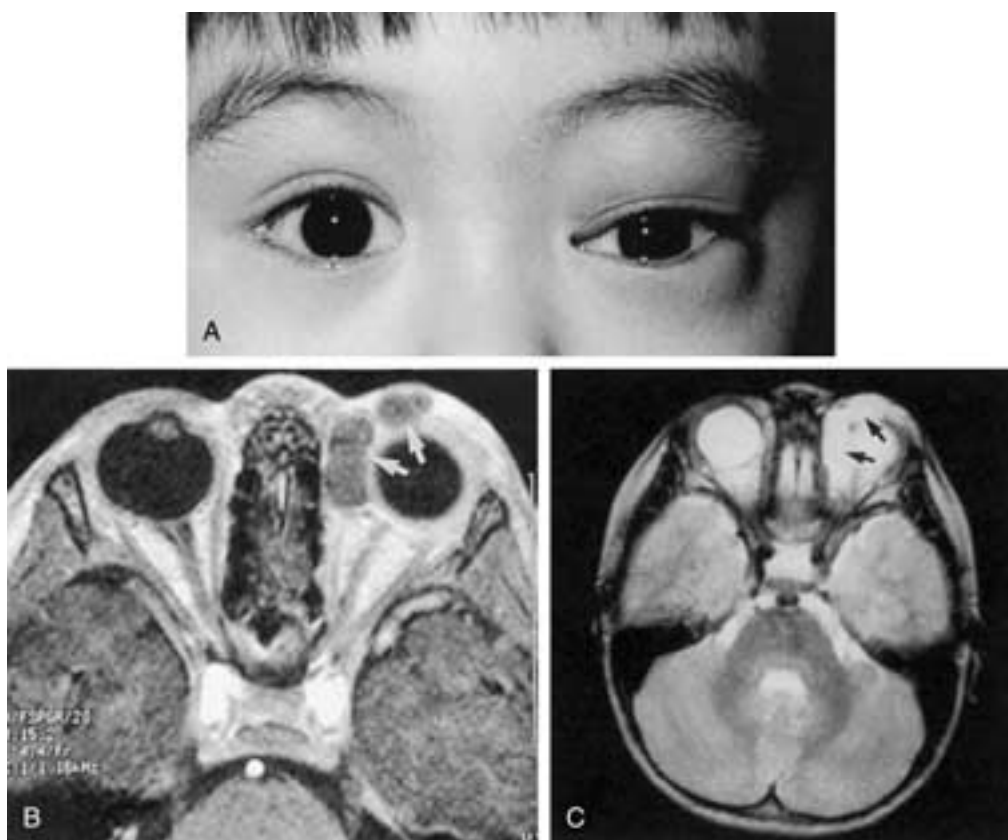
A, Clinical photograph of an 8-year-old boy who presented with acute upper-lid fullness on the left and inferior displacement of the globe caused by hemorrhage within a lymphangioma. B, Axial-enhanced T1-weighted MR image shows a lobular mass (*arrows*) in the anteromedial left orbit. The signal intensity of the lesion is hyperintense to vitreous and isointense to brain. There is no contrast enhancement. C, Axial T2-weighted MR image shows that the lesion (*arrows*) is homogeneously hyperintense to brain and isointense to vitreous. (From Kaufman LM et al. Diagnostic imaging of cystic lesions in the child's orbit. *Radiol Clin North Am* 1998;36:1149–1163.)
